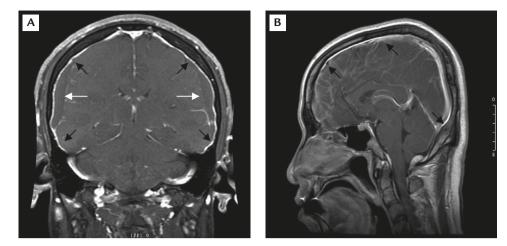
T1-weighted magnetic resonance images of the brain with intravenous contrast medium injection demonstrate prominent dural (pachymeningeal) enhancement diffusely (black arrows), subacute subdural hematoma (white arrows) and brain descent with obliteration of the basal cistern. (A) Coronal view; (B) sagittal view.
